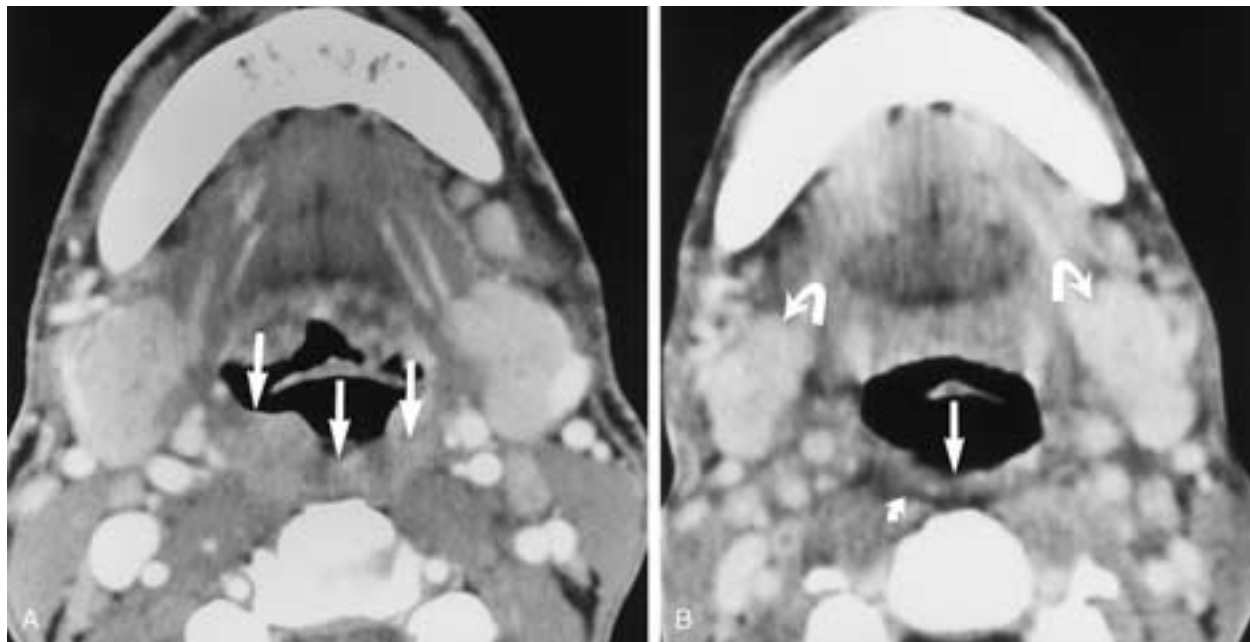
A, Axial contrast-enhanced CT scan demonstrates a tumor involving the posterior wall of the oropharynx (arrows) with bilateral nodal disease. B, Following RT, there is a marked reduction in the size of the tumor, with residual thickening of the posterior wall of the oropharynx (straight arrow). Retropharyngeal space edema (small curved arrow) and mild atrophy of the submandibular glands (large curved arrows) are normal changes resulting from RT.
